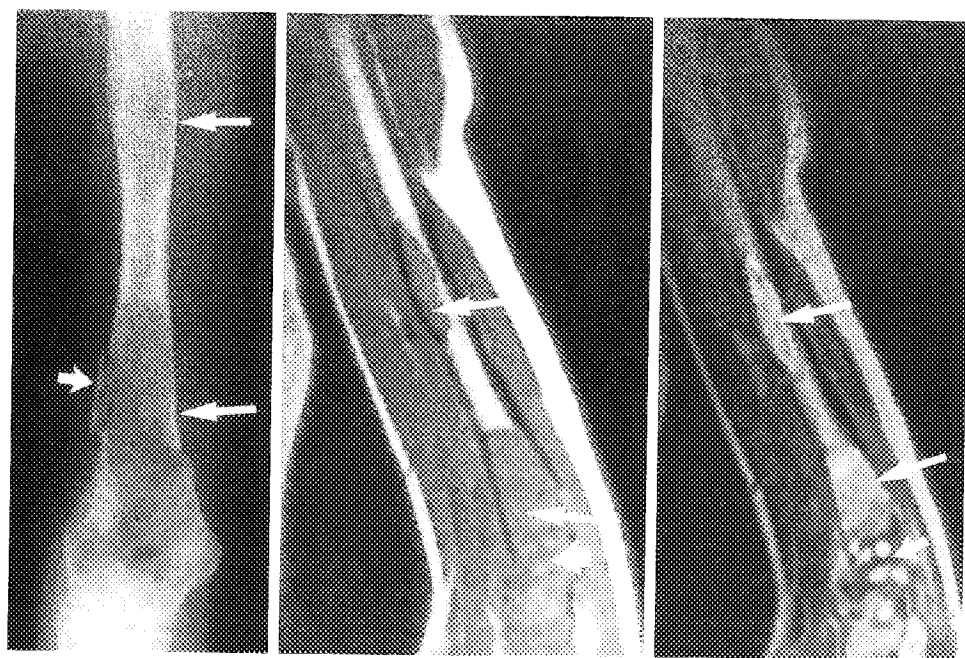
Fibrous dysplasia of the humerus as imaged by radiography (*left*), coronal T₁-weighted MR scan (*middle*), and T₂-weighted MR scan (*right*). The radiograph shows two sites of fibrous dysplasia (*large arrows*) and a pathologic fracture (*small arrow*). The lesions show a reduced T₁ signal and an intermediate T₂ signal surrounded by a hyperintense rim (*large arrows*). (From Utz *et al.* [42*]; with permission.)
